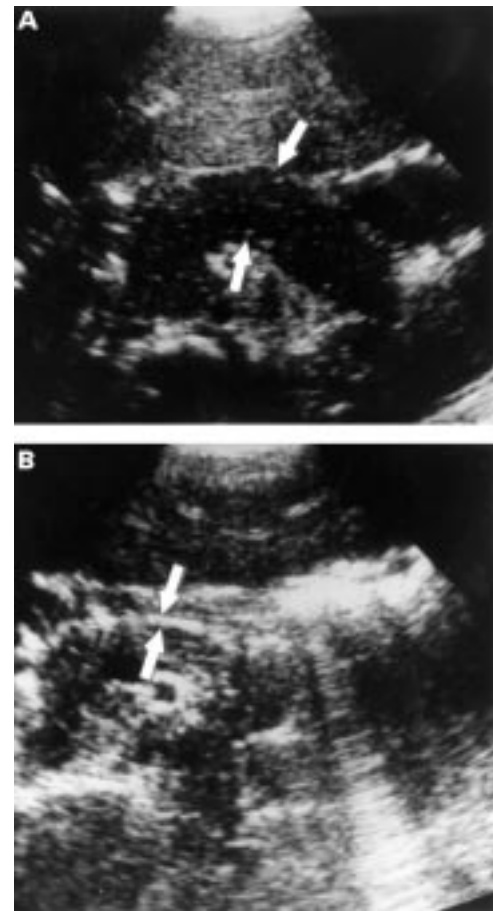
Abdominal sonogram of patient 4. Panel A shows diffuse pancreatic enlargement at presentation (arrows). Panel B reveals pancreatic atrophy 15 months later (space between arrows).
